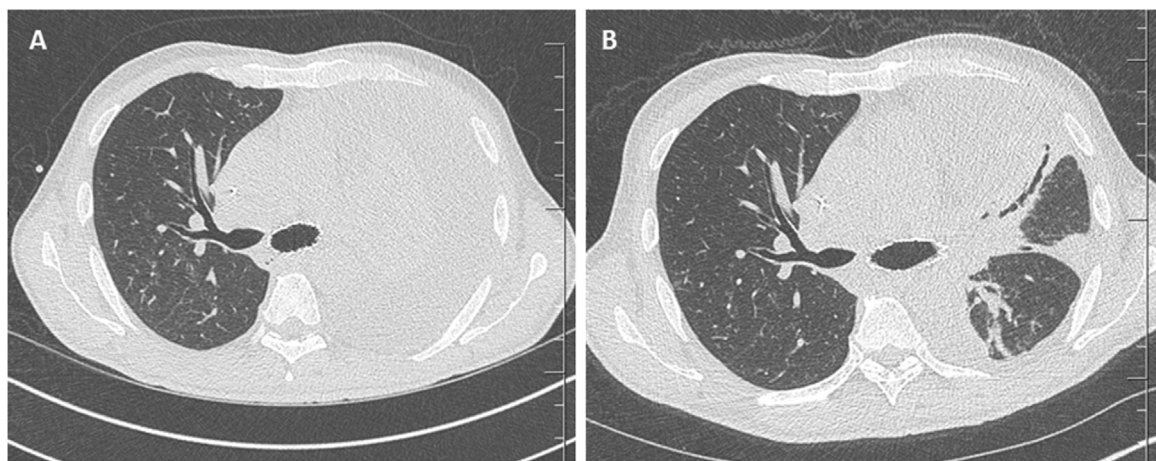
A and B: CT images at one and two months of treatment, respectively.
